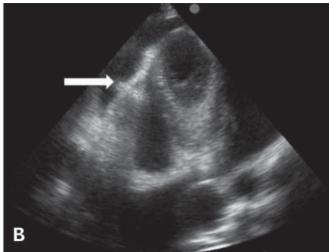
(A) Huge pericardial effusion surrounding the heart was evident on transthoracic echocardiography. (B) Arrow indicates the Seldinger needle in the pericardial space.
